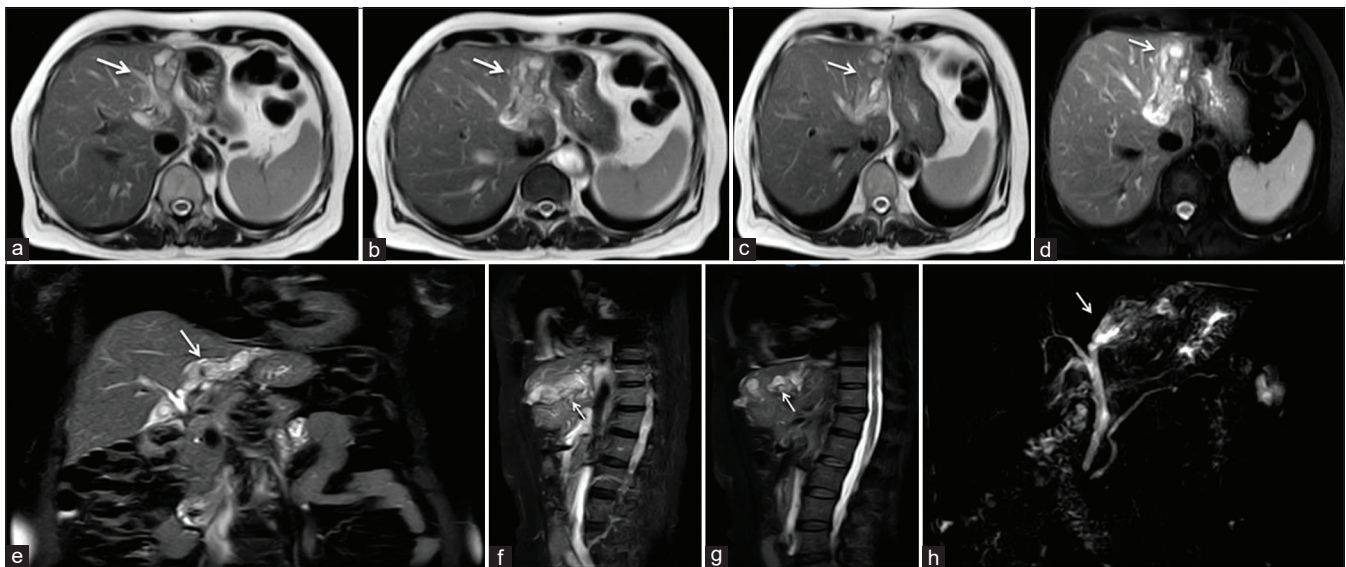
T2-weighted abdominal magnetic resonance images in axial (a-d), coronal (e) and sagittal (f and g) planes demonstrate a T2 high signal intensity lesion in the left liver lobe accompanied with intrahepatic biliary duct ectasia and parenchymal shrinkage without signal change on fat saturation sequences (d-g) Magnetic resonance cholangiopancreatography image (h) shows similar findings as intrahepatic biliary duct ectasia of left liver lobe accompanied with an area of filling defect within dilated biliary ducts showing branching distribution
